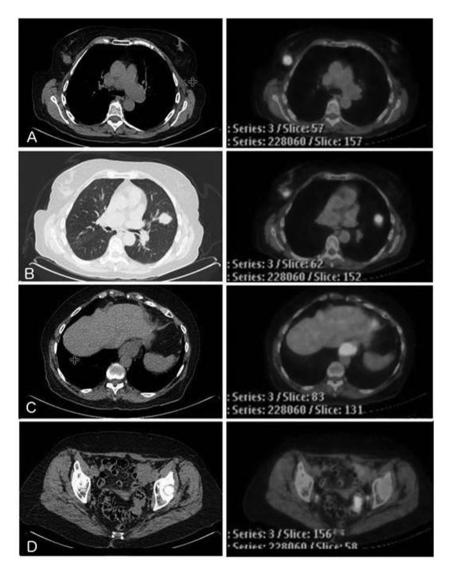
Fluorine-18-fluorodeoxyglucose positron-emission tomography with computed tomography. A: Right breast mass, maximal standardized uptake value (SUV) of 14.5. B: Spiculated left upper lobe mass, maximal standardized uptake value (SUV) of 7.4. C: Distal esophageal wall thickening, maximal standardized uptake value (SUV) of 16.2. D: Segment of sigmoid wall thickening, maximal standardized uptake value (SUV) of 12.0.
